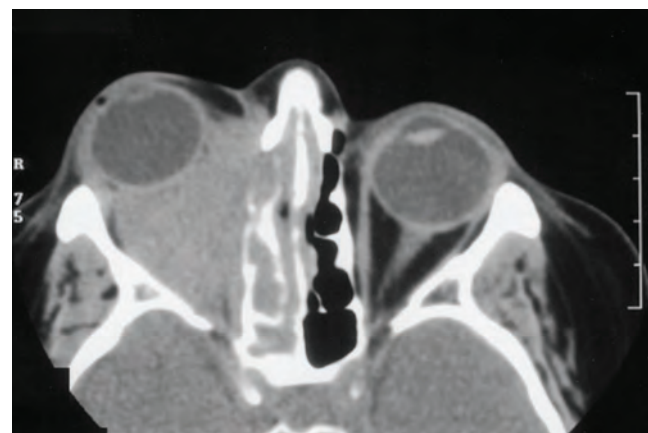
Figure e40-5 Computed tomography of the orbits in a patient with granulomatosis with polyangiitis (Wegener's), who presented with right-eye proptosis. The image demonstrates inflammatory tissue extending from the ethmoid sinus through the lamina papyracea and filling the orbital space.
